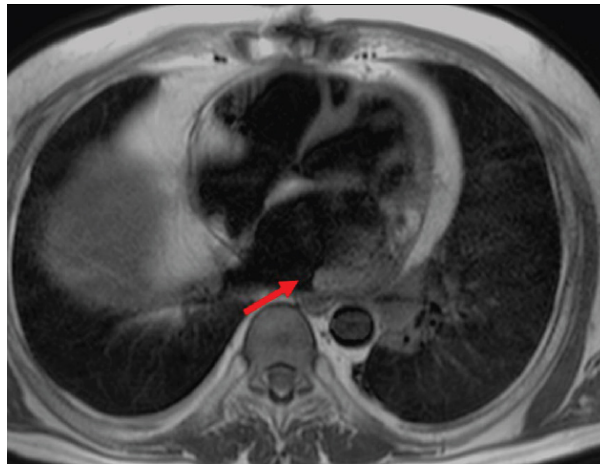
Post-treatment MRI imaging T1w showed volume reduction of sarcoma without pulmonary vein involvement.
